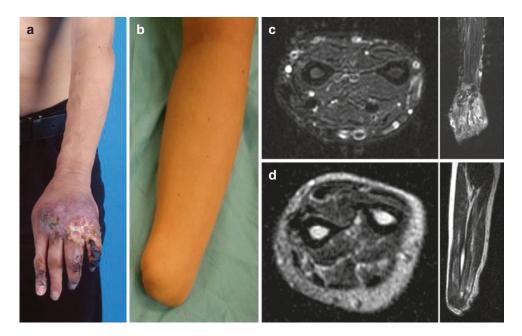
CC: hand necrosis. Dx: Arteriovenous malformation. (a) preop picture. (b) postop picture: hand amputation. (c) preop MRI. (d) postop MRI
